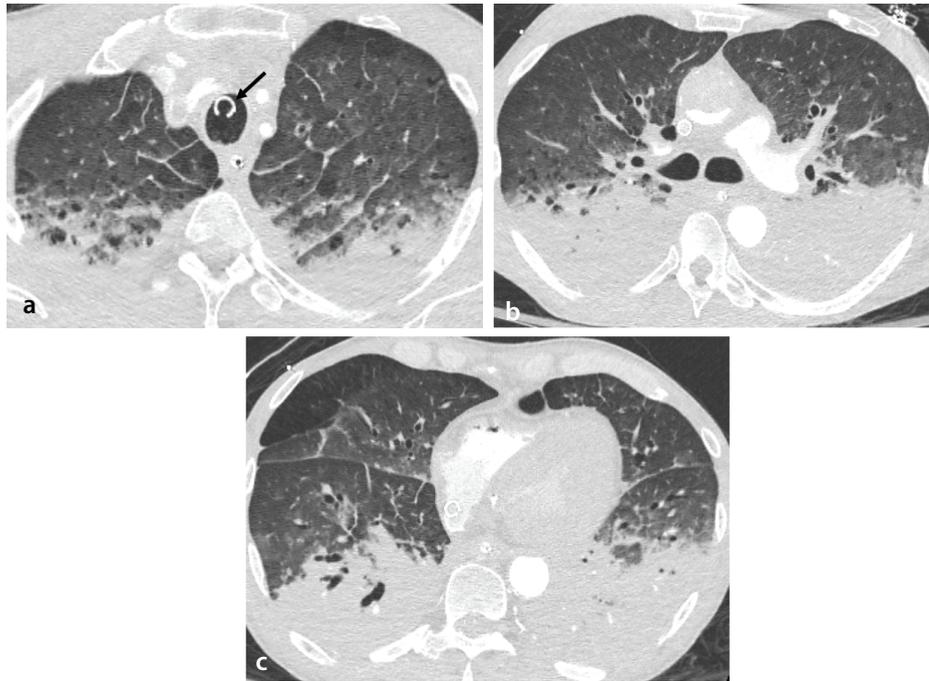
Diffuse alveolar damage pattern on chest computed tomography (CT). Axial CT images (a–c) demonstrate dependent gradient of consolidations, consistent with the exudative phase of diffuse alveolar damage. The patient experienced respiratory deterioration and met clinical criteria for acute respiratory distress syndrome. The endotracheal tube is noted (arrow), along with interstitial thickening, suggestive of underlying pulmonary edema.
